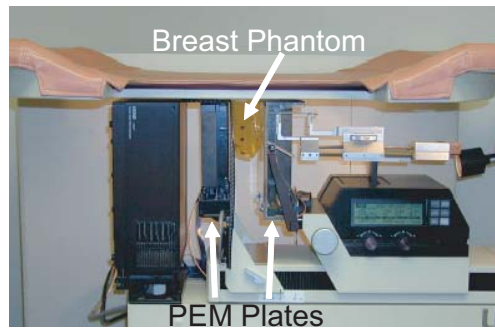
The PEM Flex system mounted in a stereotactic x-ray mammography unit. From [69].
